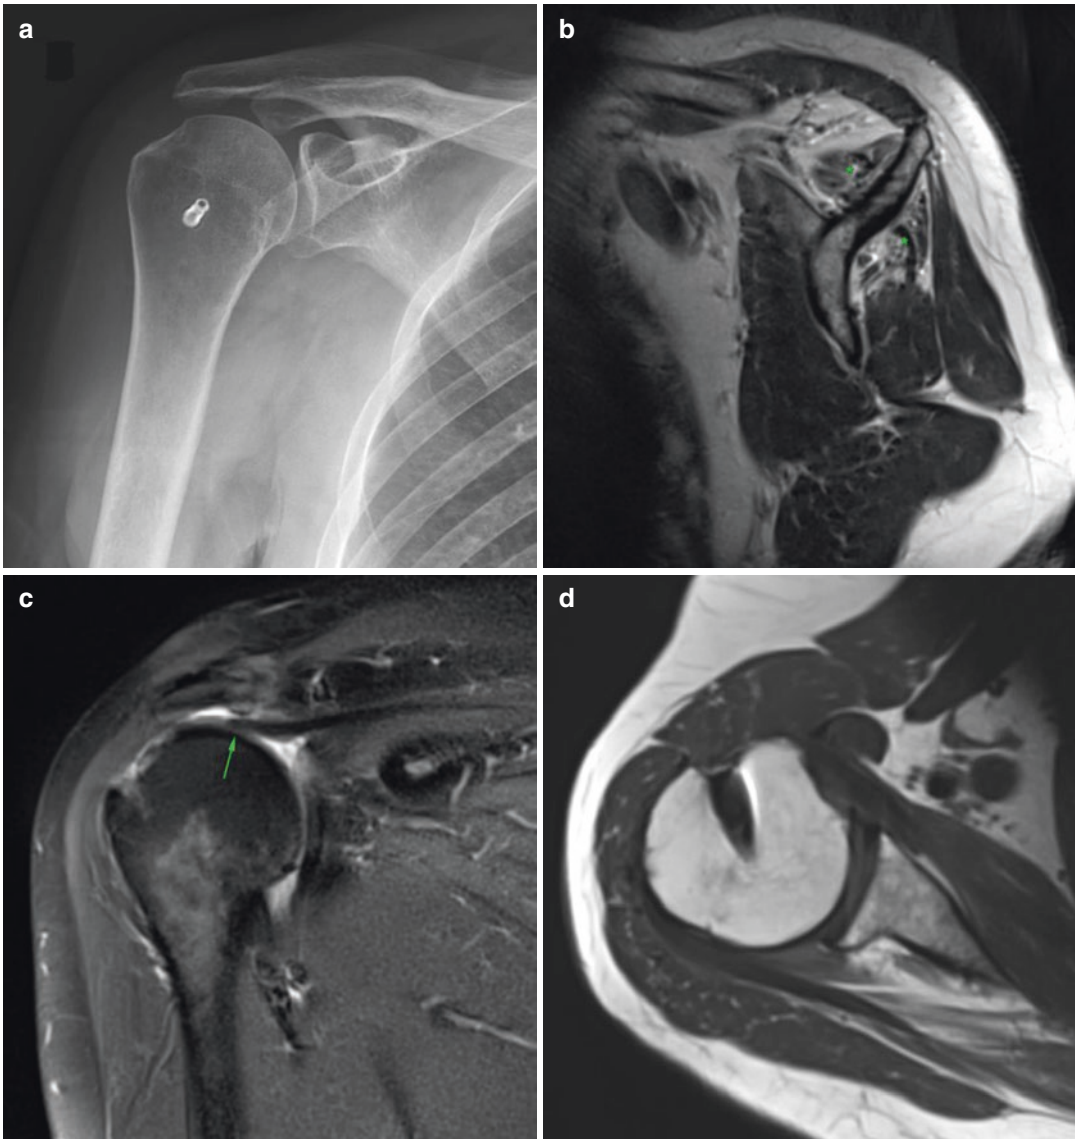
(a–d) Cuff repair follow-up. Long head of the biceps tenodesis. (a) Frontal radiograph of the shoulder shows a metallic anchor or interference screw in the humeral metaphysis. (b) T2-weighted sagittal MR image at the level of the spine of the scapula. There is massive atrophy and fatty degeneration of the supraspinatus and infraspinatus muscles (Thomazeau Stage 3), most likely beyond repair (asterisks). (c) Postoperative T2-weighted
